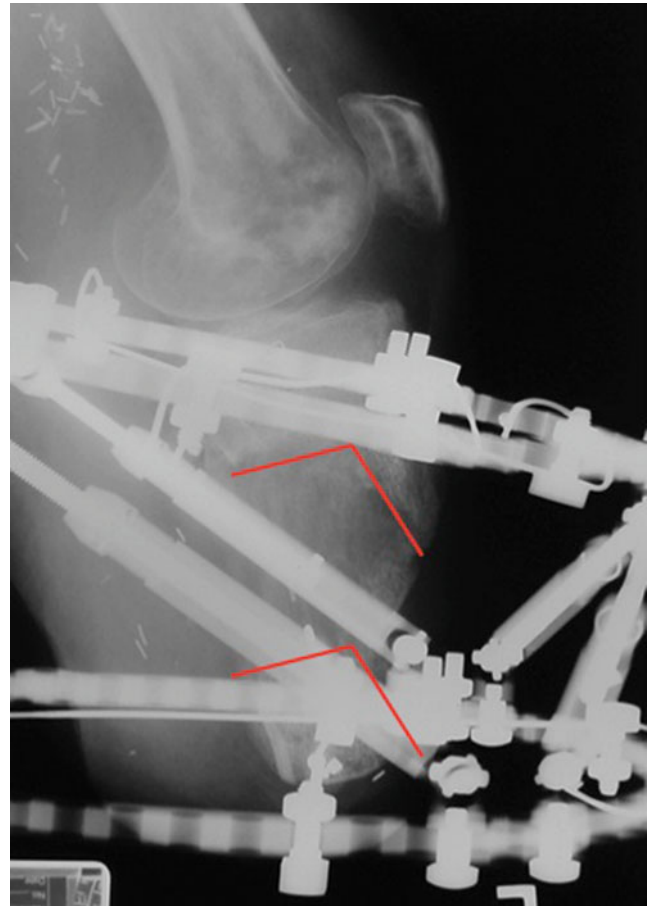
Final lateral X-ray prior to Ilizarov frame removal. Day 274 in Ilizarov. Note spatial frame struts were substituted for the initial distraction rods in order to assist with residual deformity correction
